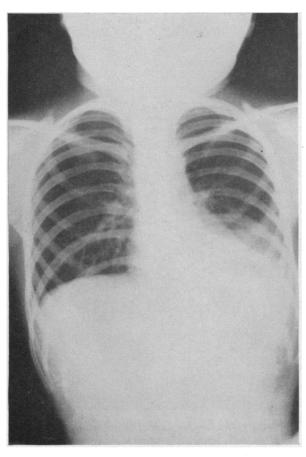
Roentgenogram of chest on January 17, 1958, showing improved aeration in lower left lobe.
